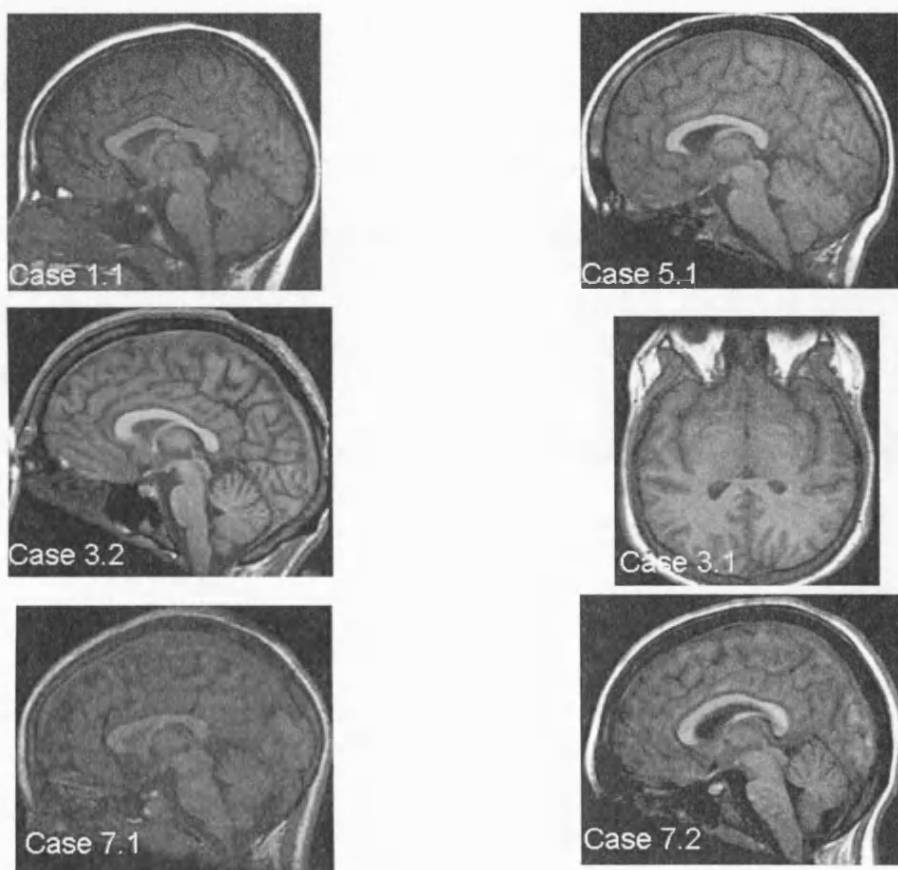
Brain MRI of cases 1.1, 3.1, 3.2, 5.1, 7.1 and 7.2
